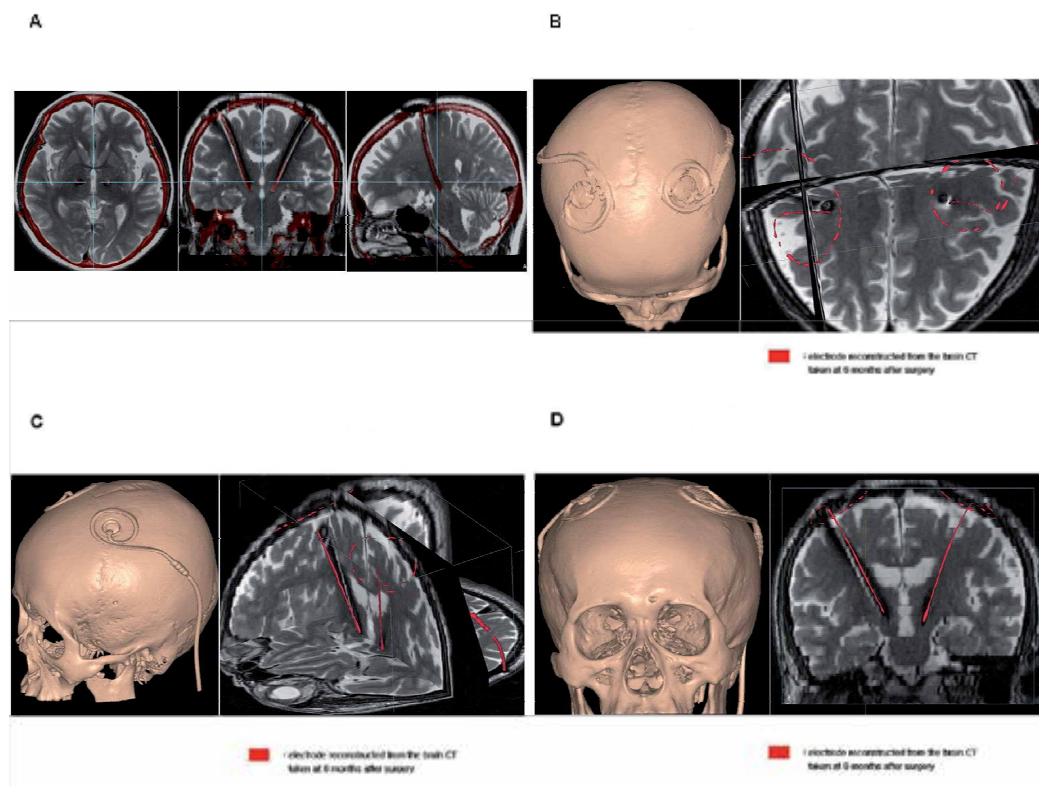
Fused images of brain CT and brain MRI, both taken 6 months after bilateral subthalamic nucleus stimulation.
